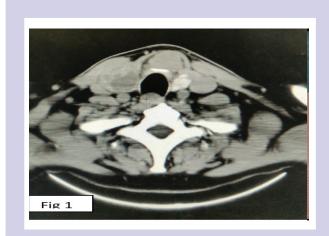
CT scan of neck showing malignant nodules in the right lobe and isthmus of thyroid.
